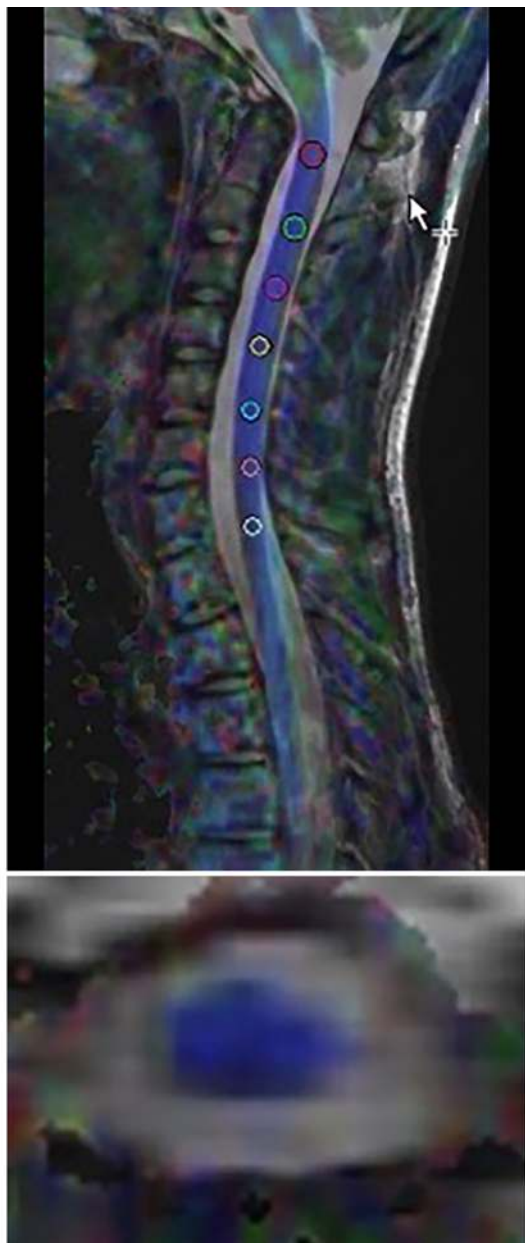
An example of sagittal (upper) and axial (lower) images that fuse the colored FA map onto a T2-weighted MR image by using post-processing software (SyngoVia VB30A; Siemens Healthineers) so that regions of interest can be selected and quantitative data can be acquired.
